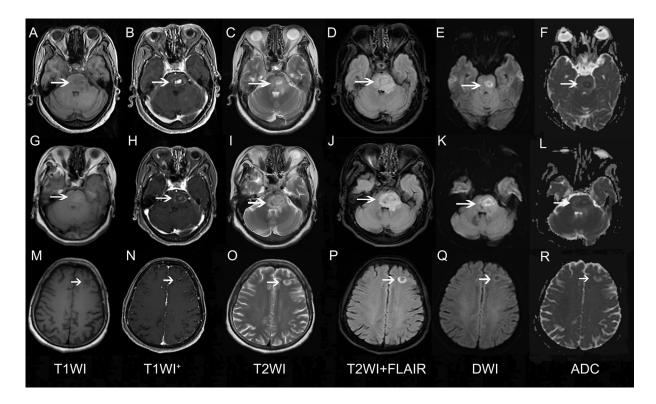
(A-F) Brain magnetic resonance imaging (MRI) at admission showed a 2.1 x 1.4 x 1.1cm area of low signal intensity on T1WI (A) and ADC (F), high signal intensity on T2WI (C), FLAIR sequence (D) and DWI (E) with peripheral edema. The lesion showed moderate ring enhancement with a central enhancement nodule on T1WI (B) and involved the mesencephalon and left cerebellar peduncles, with compression of the fourth ventricle. A repeat brain MRI one week after admission showed a slightly enlarged pontine lesion (G-L) and a new lesion in the left frontal lobe (M-R).
